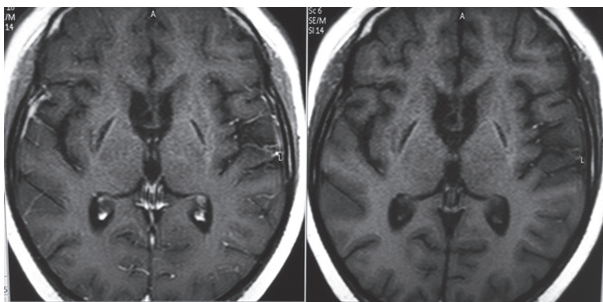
Cranial MRI, axial slice, T1 with and without contrast, respectively
